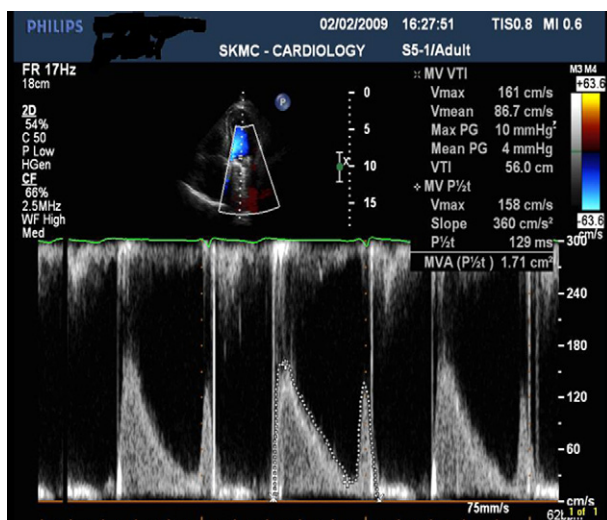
Continuous wave Doppler study showing a significant drop in the pressure gradient across the prosthetic mitral valve after tenecteplase.
